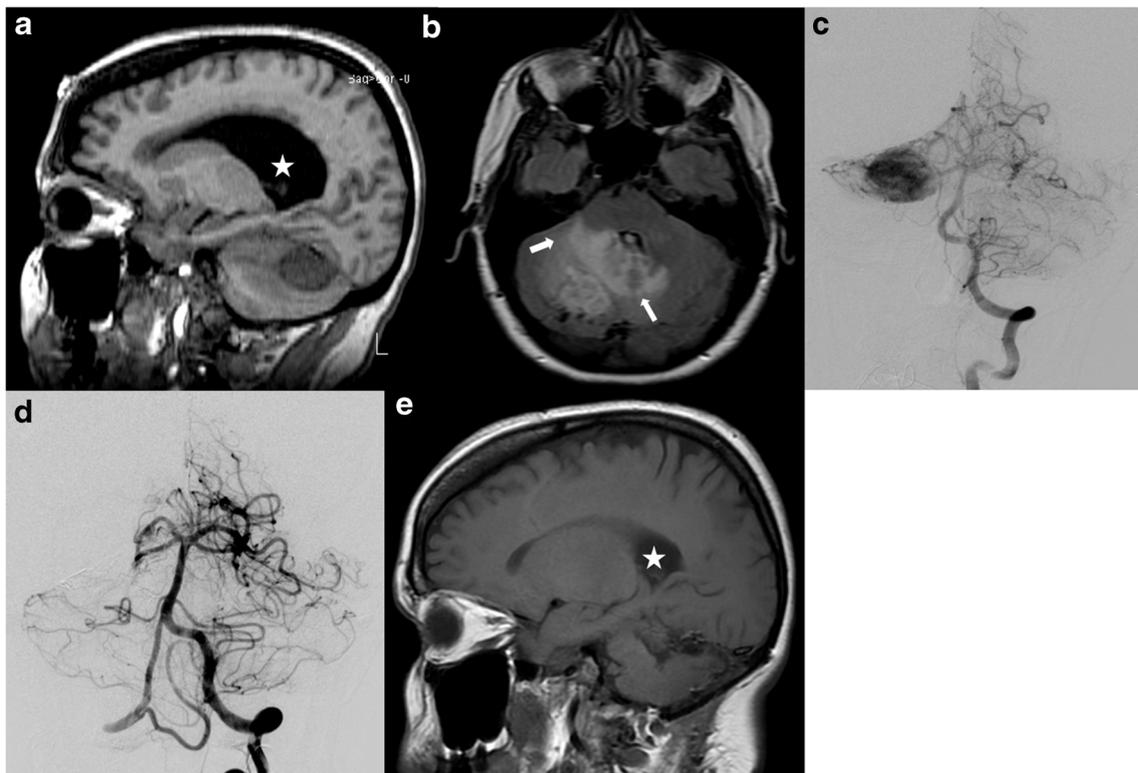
A 40-year-old female, 16 weeks pregnant (gravidia 1, para 0, 1 miscarriage), presented with headaches, vomiting, and blurry vision which developed over the course of few weeks. Her headaches were occipitally located and exacerbated by Valsalva and vomiting. She also developed new onset diplopia approximately 1 week prior to admission. On admission, her neurological examination was only positive for bilateral nystagmus as well as mild dysmetria. Non-contrast magnetic resonance imaging (MRI) of the brain revealed a $2.9 \times 2.3 \times 2.5$ -cm subtentorial mass, associated with surrounding edema with mass effect on the dorsal brain stem and partial effacement of the fourth ventricle resulting in hydrocephalus with transependymal edema, and tonsillar herniation. Slightly prominent subadjacent flow void was also noted. There was no associated tumoral cyst. a Non-contrast, T1-weighted image, sagittal view. Significant obstructive hydrocephalus is demonstrated (*white star*). b Fluid attenuation inversion recovery (FLAIR) image, axial view. Significant hyperintensity surrounding the lesion is noticed, compatible with peritumoral edema (*arrows*). Patient underwent digital subtraction angiography (DSA) and tumor embolization using Onyx 18 (EV3, Inc., USA). c DSA images after left
